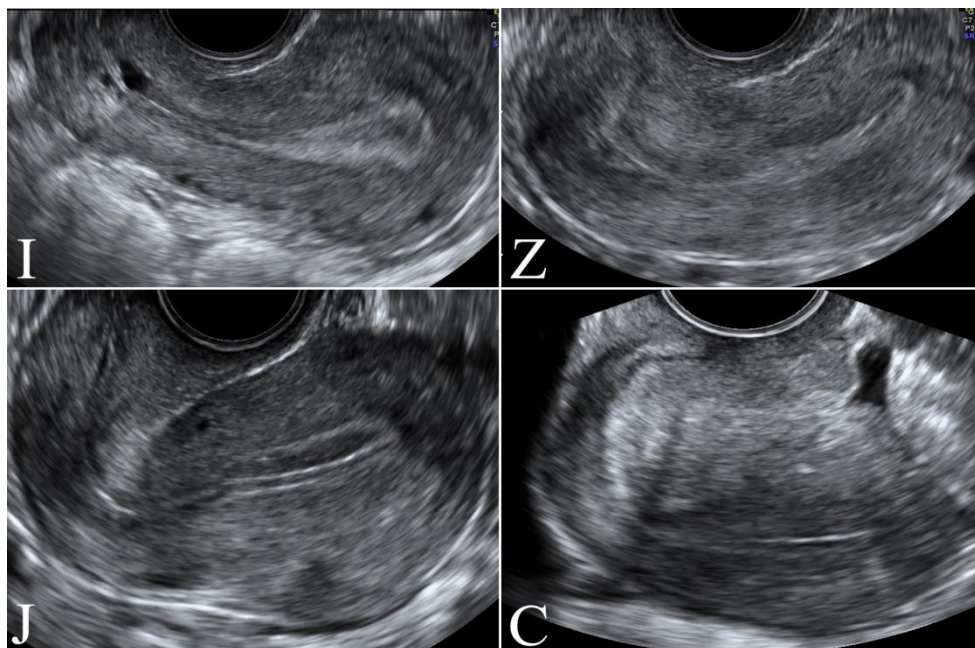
Most common cervical canal shapes viewed during ultrasound examination: I) type “I” – the cervical canal is straight, J) type “J” – the cervical canal bends one time, Z) type “Z” – the cervical canal bends at least two times in the opposite directions, C) type “C” – the cervical canal bends at least two times in the same direction.
